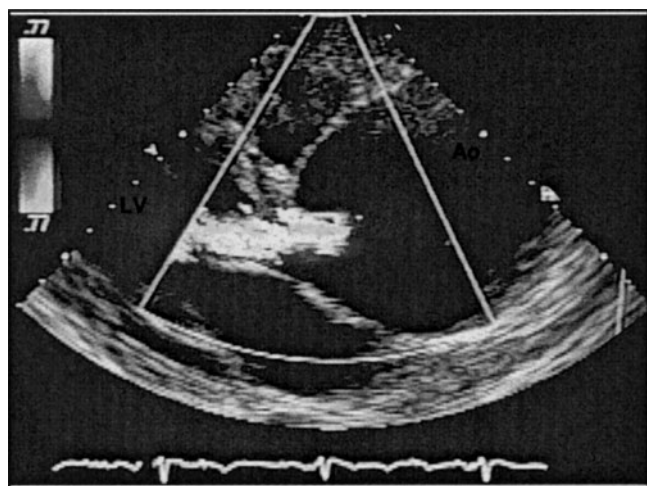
Annuloaortic ectasia associated with aortic regurgitation diagnosed by transthoracic echocardiography. Ao = aorta; LV = left ventricle.
